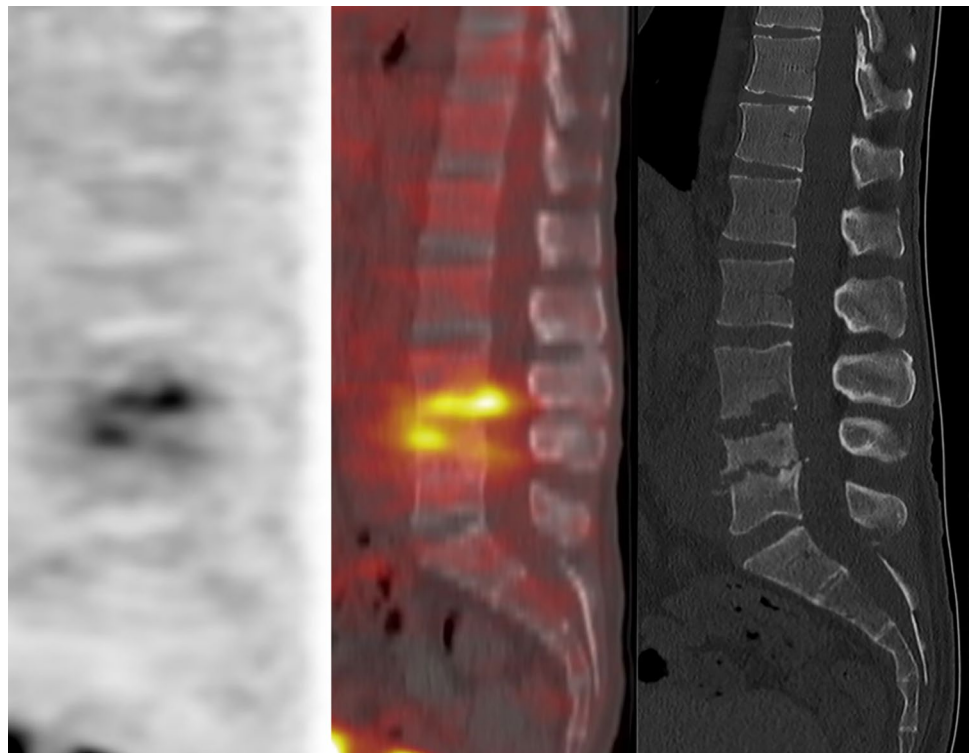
Spondylodiscitis with bone destruction. A 46-year old man with recent spondylodiscitis at level L4-L5 with psoas abscess, resulting from *S. aureus* bacteremia. Portal of entry was not identified. Treatment included abscess drainage and intravenous flucloxacilline. After approximately 3 months, there was recurrence of back pain, subfebrile temperature and blood cultures were again positive for *S. Aureus*. [^{18}F]FDG PET/CT shows normal uptake at level L4-L5, but increased uptake at level L3-L4 (sagittal PET and fused PET/CT images at left and middle panels). Diagnostic CT shows bone destruction of the L4 vertebra with erosion of the endplates and loss of height (right panel)
